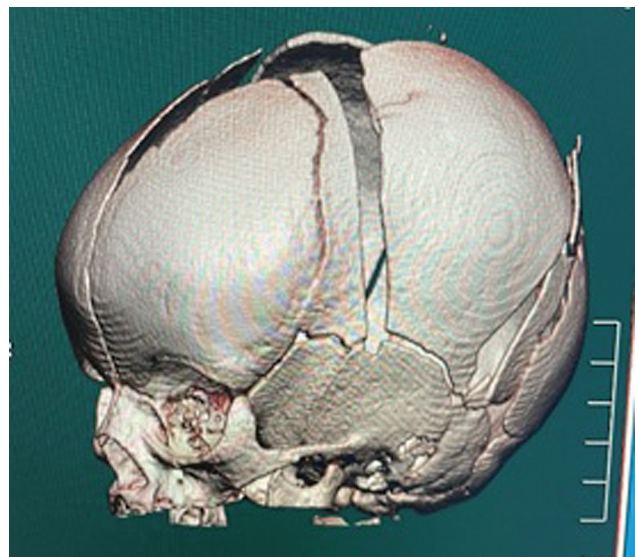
5 CT scan 3 days after remodulation surgery.
